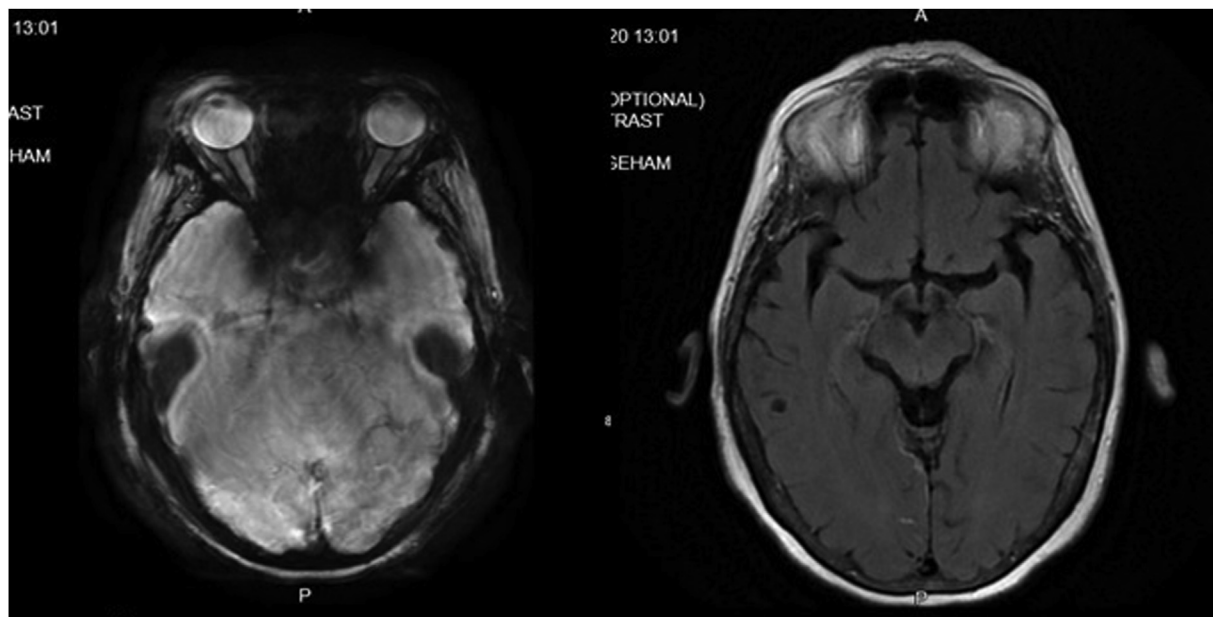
MRI brain showing leptomeningeal enhancement and cyst appearing foci in the temporal lobe.
